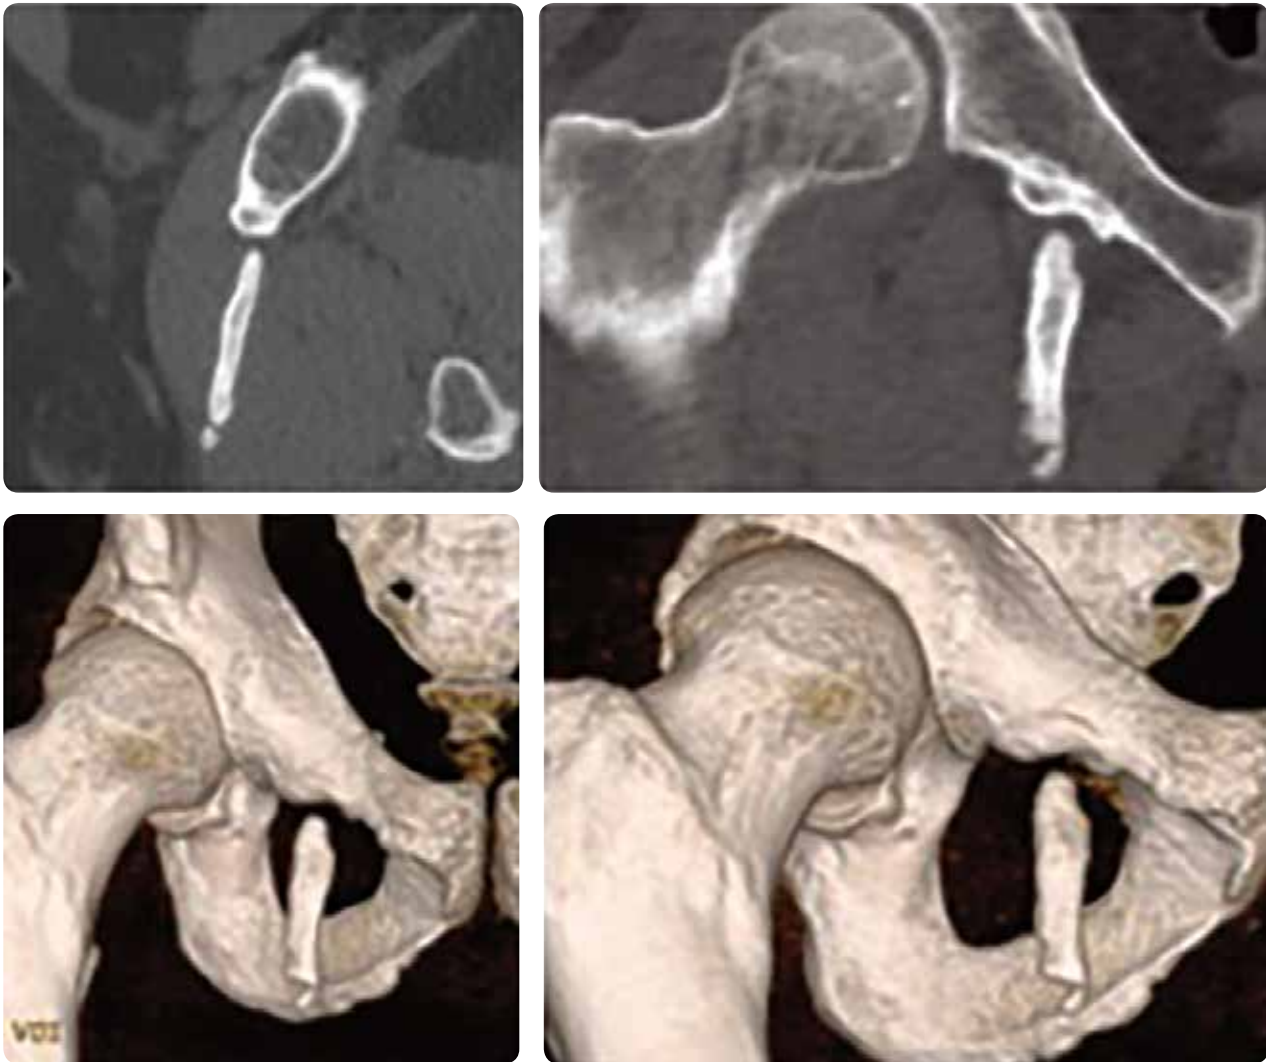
Sagittal and coronal sections of CT (upper) and three-dimensional reconstructions (lower): the presence of an ossified linear structure is confirmed in the soft tissues of the anterior and medial aspect of the right hip, extending from the pubis to the height of the adductor muscles.
